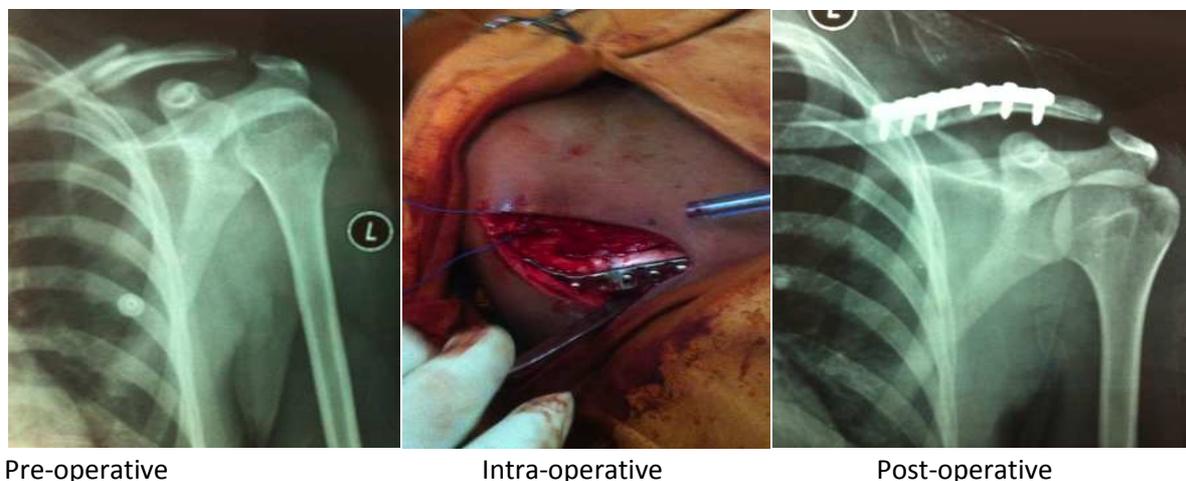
X-ray during pre-operative, intra-operative and post-operative periods.
